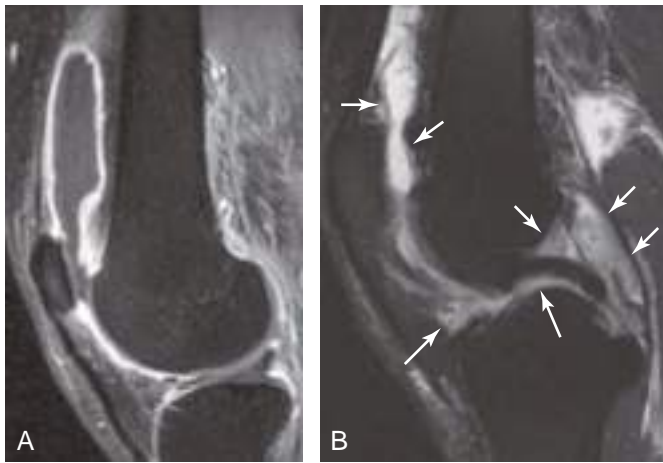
Synovitis. (A) Sagittal fat-suppressed gadolinium-enhanced T1-weighted MR image of the knee in a patient with a septic knee shows intense enhancement of uniformly thickened synovium. (B) Sagittal fat-suppressed T2-weighted MR image of the knee in a different patient with new onset of inflammatory arthritis shows bulky synovial hypertrophy. The thickened synovium is seen as intermediate signal intensity (*arrows*), compared with the higher signal intensity of joint fluid.
